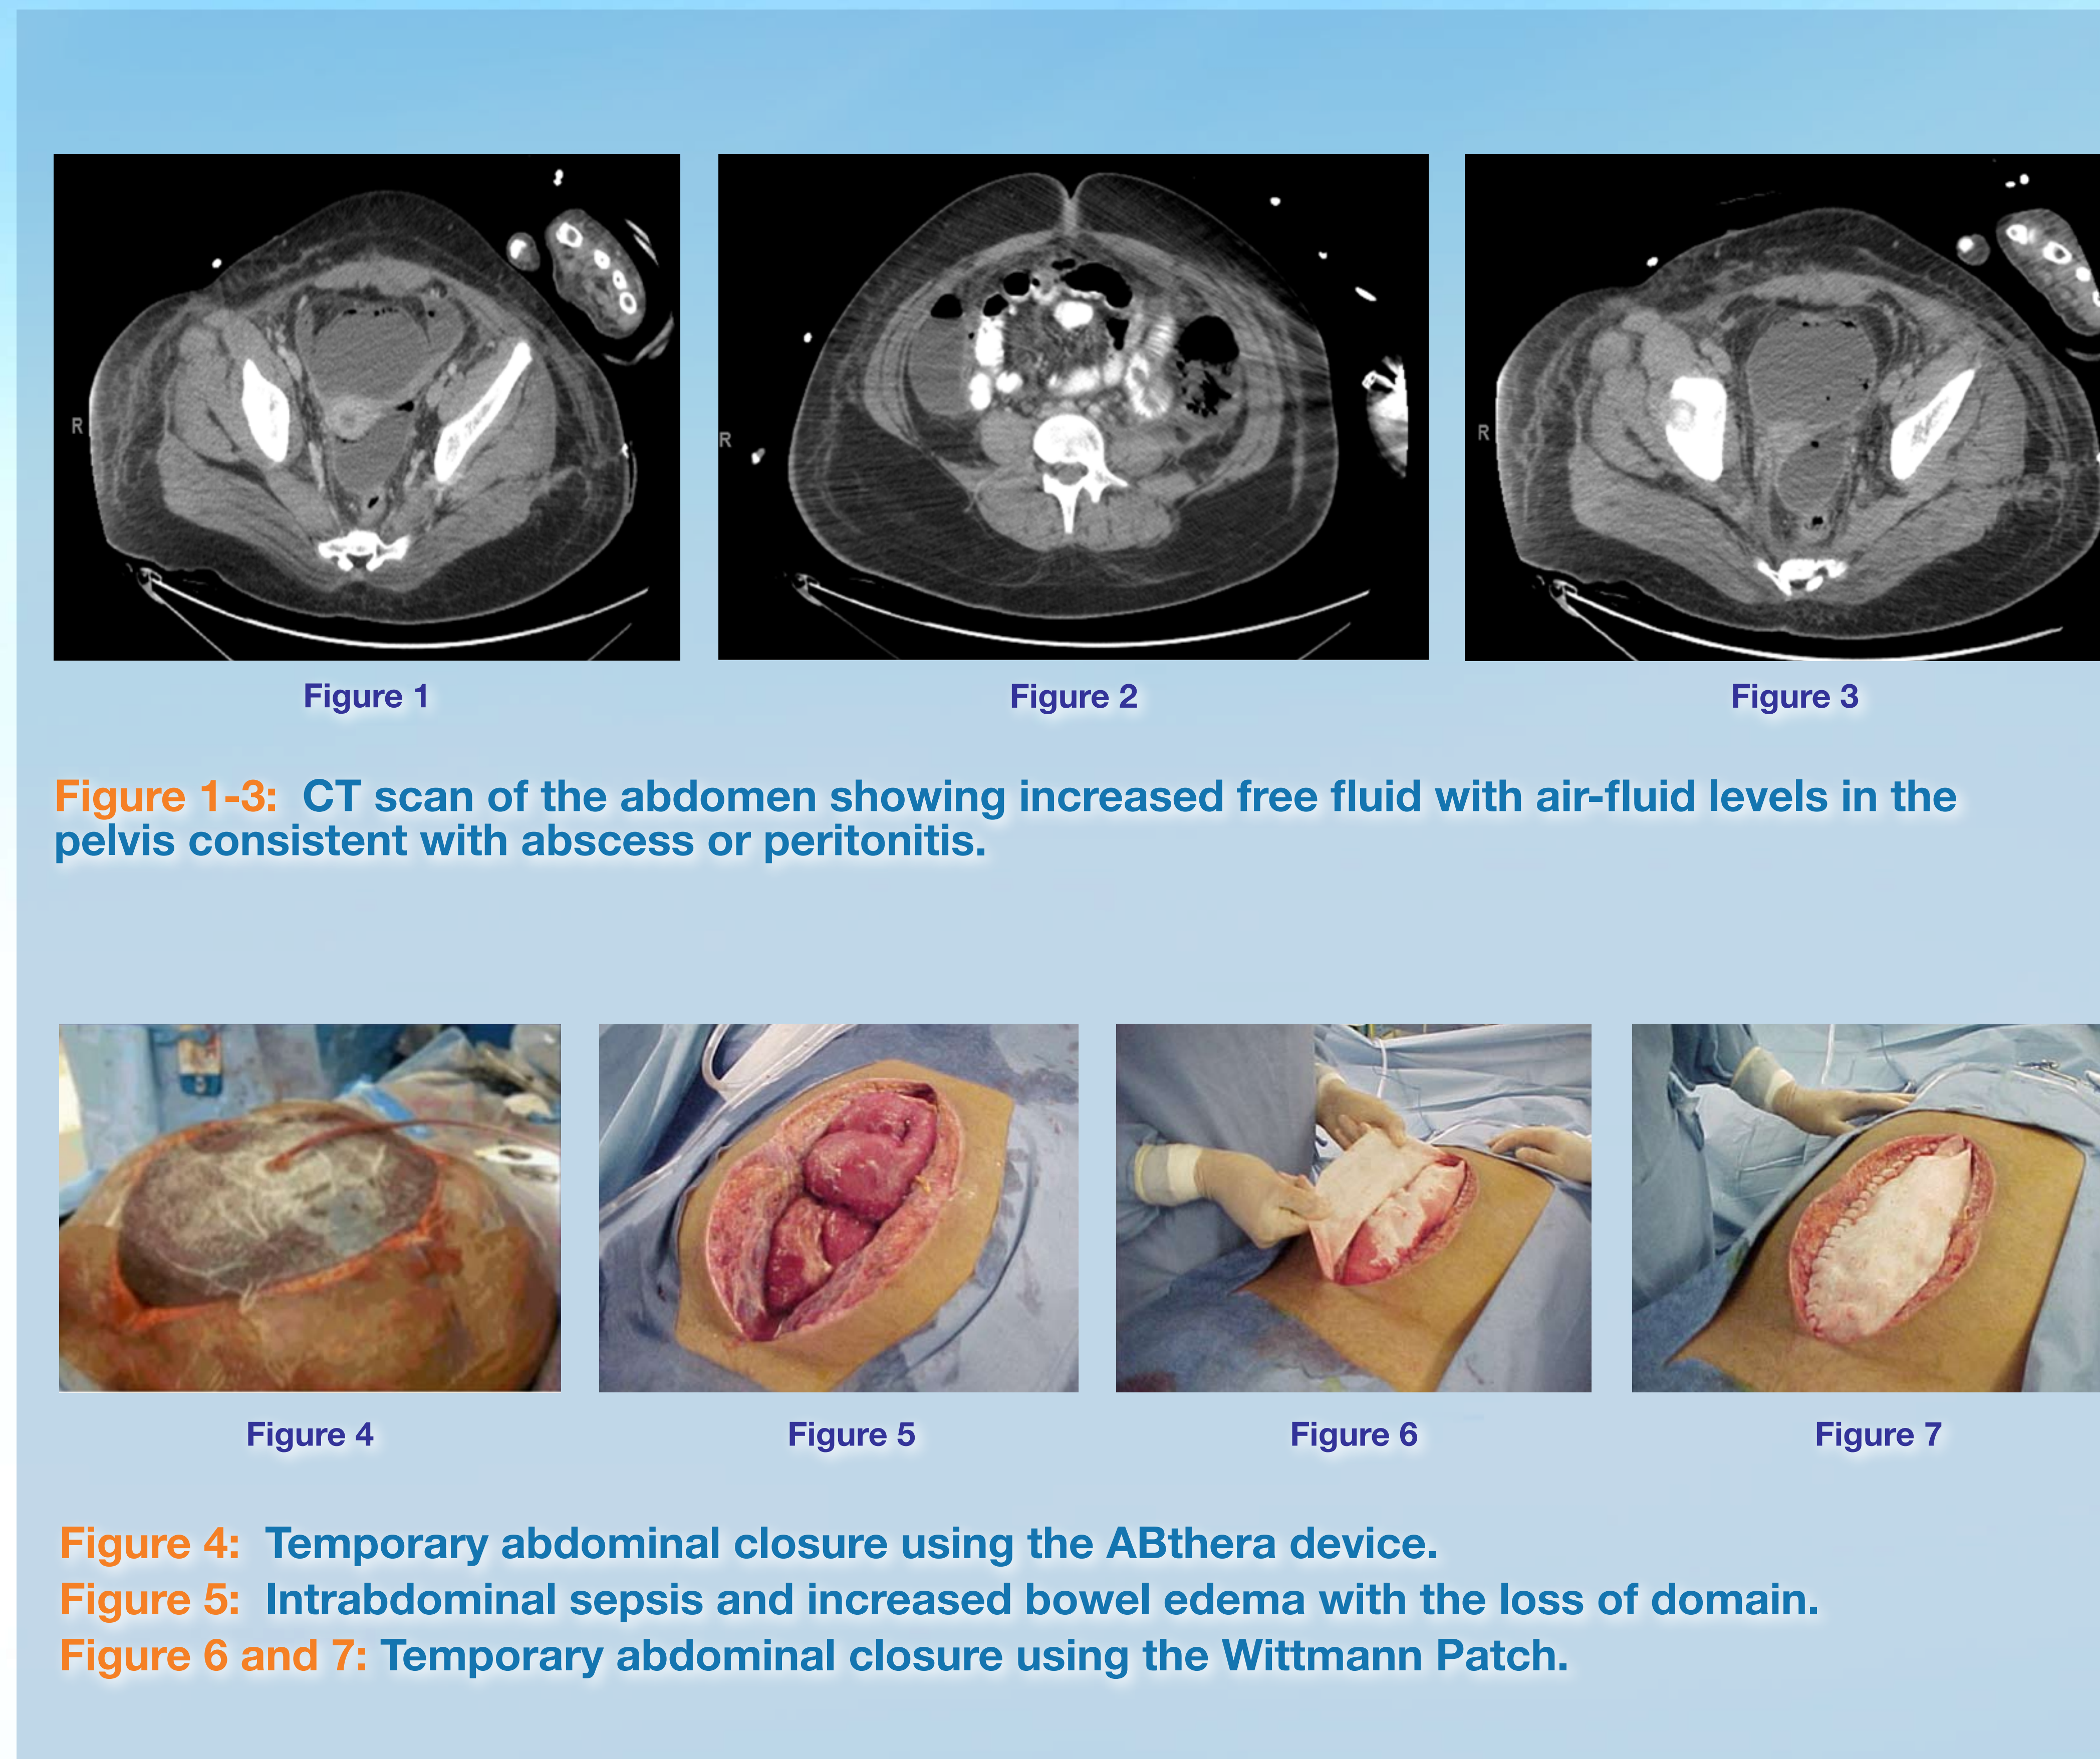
CT scan of the abdomen showing increased free fluid with air-fluid levels in the pelvis consistent with abscess or peritonitis.
